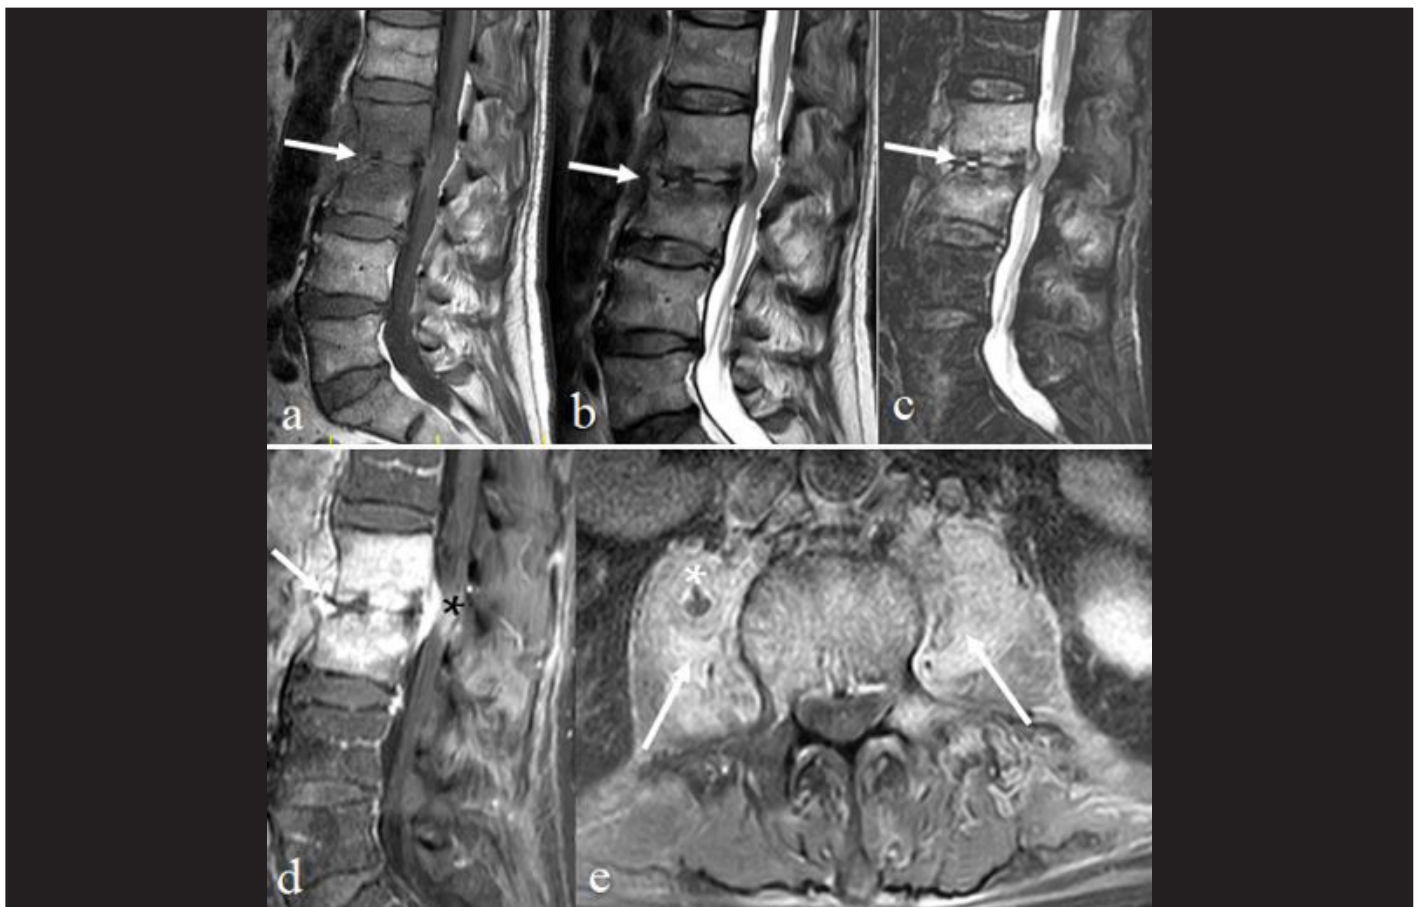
A 46-year-old male patient presented with severe back pain and fever. The patient had a 3-week history of fevers and increasing back pain. In the sagittal T1-weighted (A), T2-weighted (B), and STIR (C), fat-suppressed T1 gadolinium-enhanced (D) MR images of the thoracic spine, loss of height and increased T2 signal intensity and enhancement of the L2-3 disk are observed (white arrow). Cortical erosions with low T1 signal intensity, high T2 signal intensity, enhancement of adjacent endplates, and essentially the entirety of each vertebral body are evident. Additionally, there is high T2 signal intensity and enhancing anterior and posterior paravertebral soft tissue centered at this level, which is a concern for discitis-osteomyelitis. An anterior epidural abscess (black asterisk) spans L2-3. In the axial T1-weighted fat-suppressed gadolinium-enhanced MR image of the thoracic spine, marked enhancement of the L3 vertebral body and overlying anterior paravertebral soft tissues (white abscess) and a right paraspinal abscess (white asterisk) are visible.
